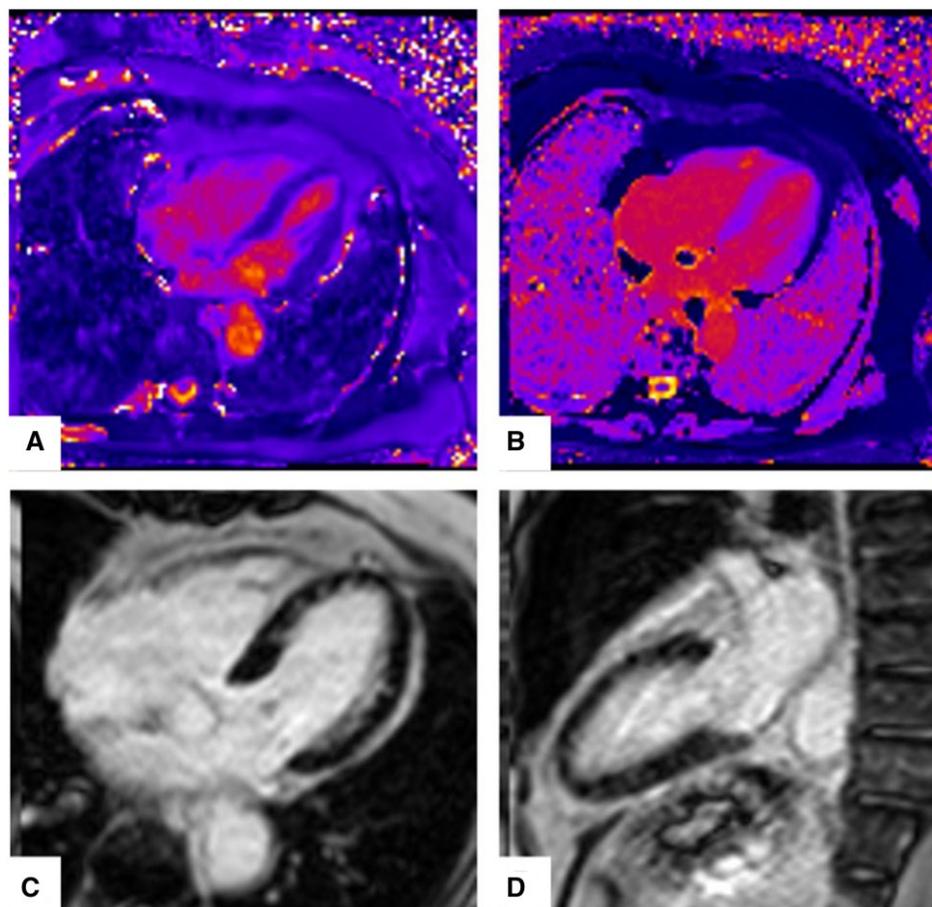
Follow-up cardiac magnetic resonance imaging at 3 months with resolving myocarditis. (A) Diffuse myocardial oedema on T2 mapping. Mean T2 = 51 ms. (B) Diffuse mid-myocardial fibrosis on T1 mapping. (C, D) Residual patchy mid-myocardial LGE.
